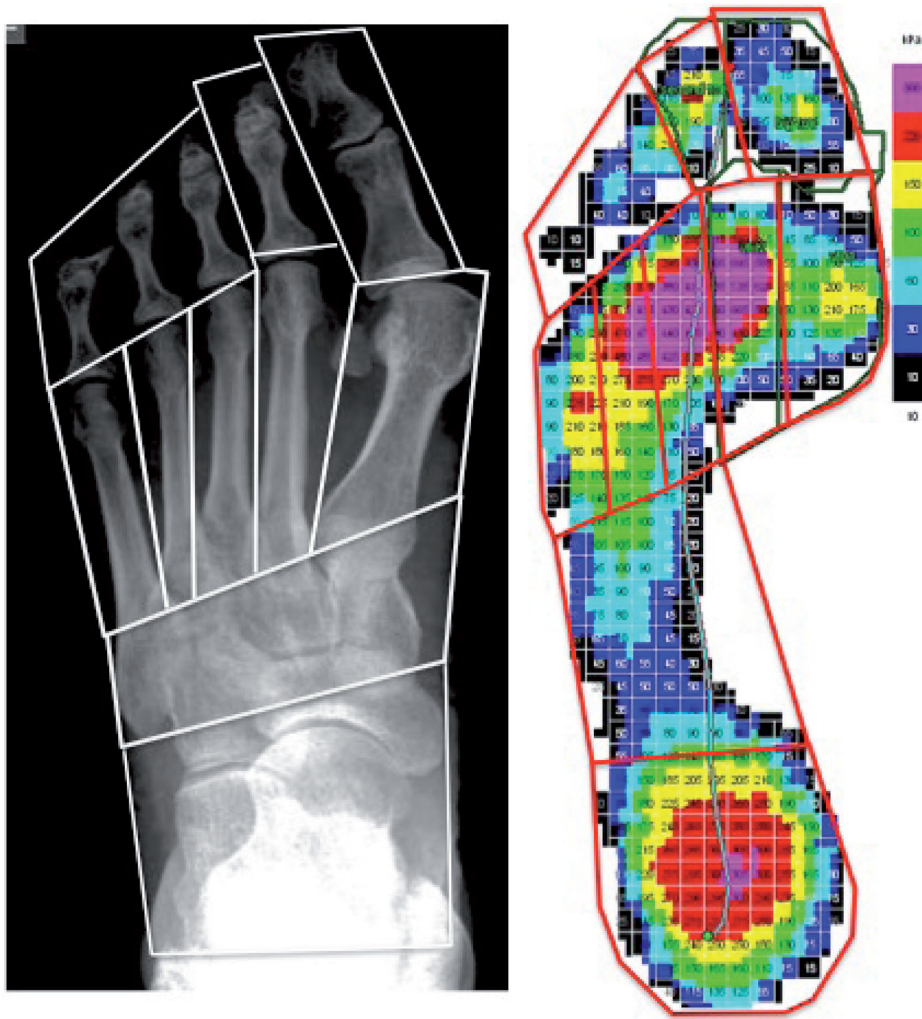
The region of interest in a plantar pressure image and the corresponding regions on a dorsoplantar radiograph. Regions: total object, heel, lateral midfoot, medial midfoot, forefoot, hallux, 2 toe, 3–5 toe, and metatarsal head 1 to 5.
